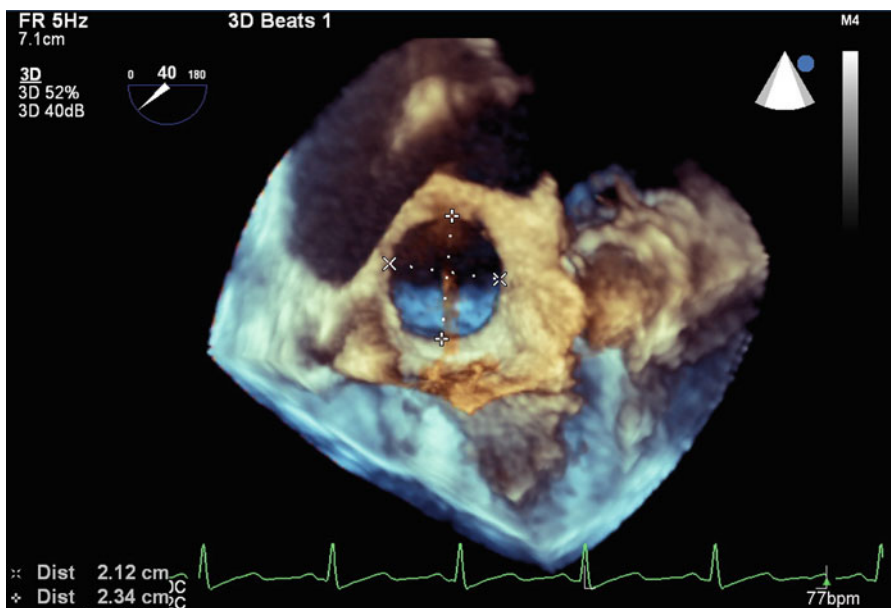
Three-dimensional transoesophageal echocardiographic images with measurements of a central circular shaped atrial septal defect
